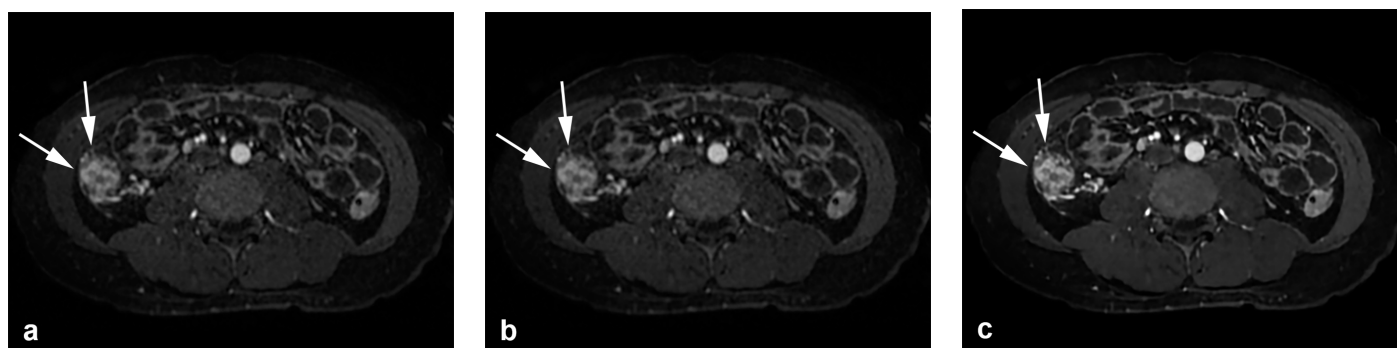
Dynamic enteric phase contrast-enhanced T1-weighted images of an 18-year-old man with active Crohn's disease. Three sets of images were obtained and reformatted in the axial plane with a 1.4-mm slice thickness: (a) with conventional reconstruction and no image filter (original); (b) with conventional reconstruction and image filter (filtered); and (c) with deep-learning reconstruction (DLR) at the noise-reduction level of 75% (DLR). The DLR image (c) better visualizes active inflammation in the ascending colon (arrows) with lower noise, a sharper margin of the bowel wall and vascularity, and better contrast of bowel wall stratification compared with the other two images (a, b). In the qualitative analysis, the DLR image was given a higher score (4 or 5) by two readers regarding overall image quality, contrast, sharpness, motion artifacts, and blurring than the other two images. The consecutive images of the same patient are also presented in Supplementary Video 1, available in the online supplement.
